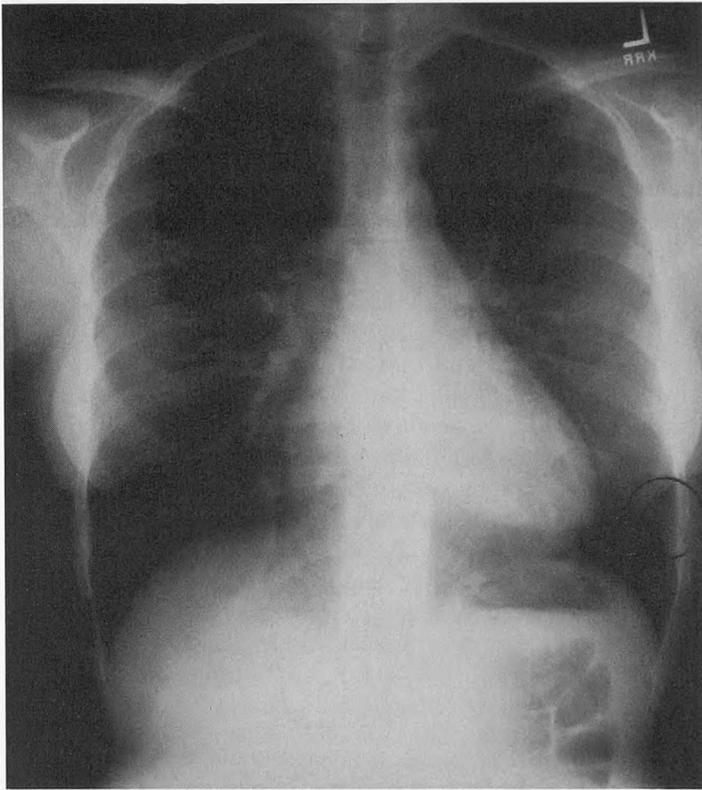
Chest x-ray film taken at the end of the competitive season revealed no abnormalities at the site of the fracture (circled area).
